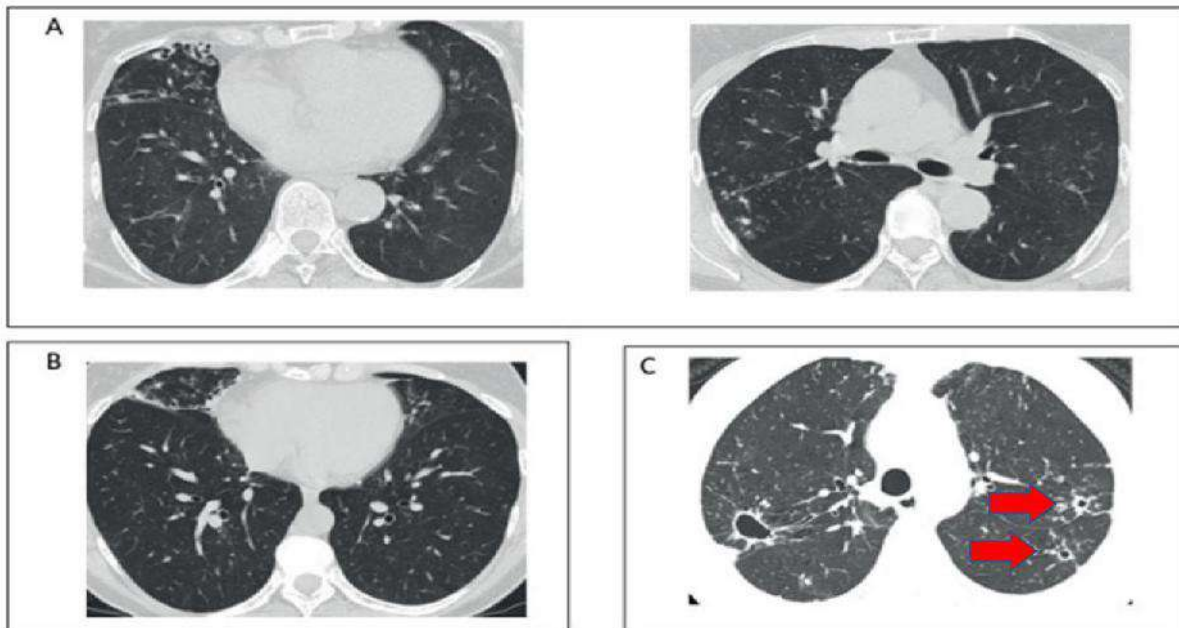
(A) A CT scan of a patient infected with *M. fortuitum*; middle lobe bronchiectasis with micronodules in the right upper lobe. (B) A CT scan of a patient infected with *M. Intercedulare*: middle lobe and lingula bronchiectasis with micronodules. (C) Cavities with solid walls in the upper lobe, micronodules in the centrilobular and "tree in the bud" in the left upper lobe¹⁷
